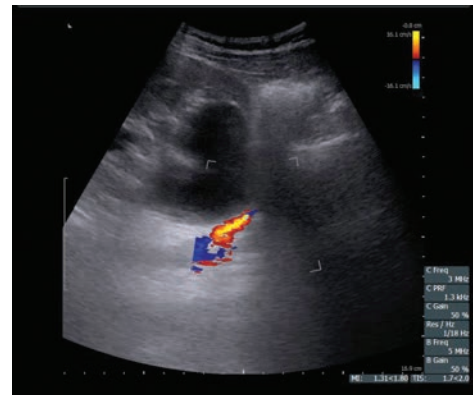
Crossing vessel at the ureteropelvic junction detected with Color Doppler ultrasound
